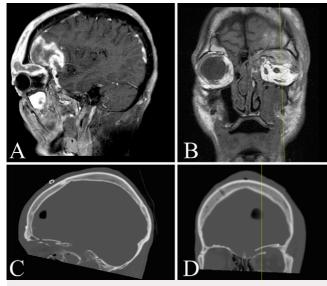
Case 1. Preoperative sagittal (A) and coronal (B) T1-weighted MRI demonstrating a left supraorbital encephalocele. Postoperative sagittal (C) and coronal (D) CT demonstrating the left reconstructed orbit.
